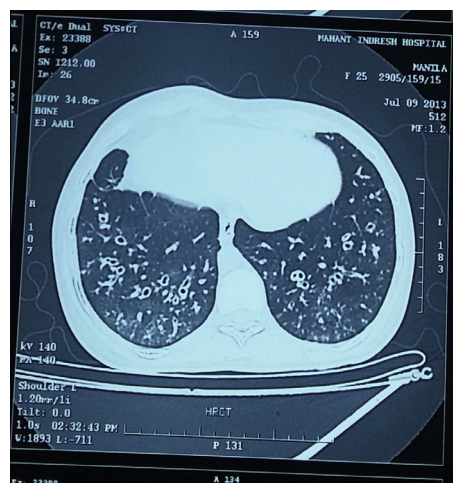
CT thorax shows bronchiectatic changes in both lower lung fields.
